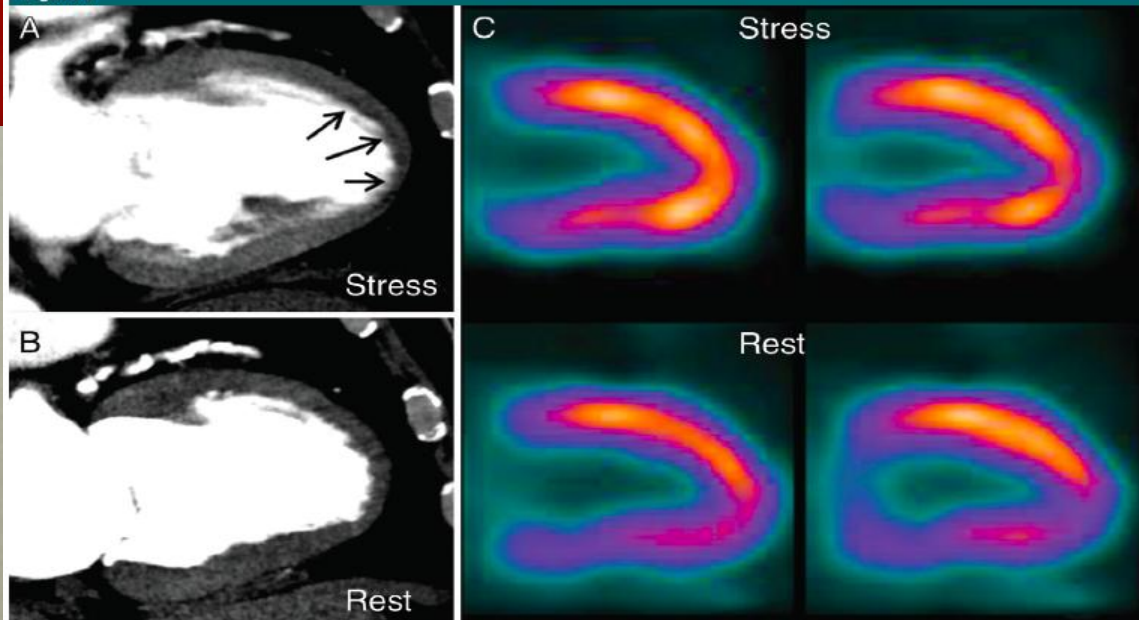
Images in 80-year-old man with chest pain. *A*, Myocardial CT perfusion image at stress demonstrates subendocardial perfusion defect in anteroapical and apical walls (arrows). *B*, Myocardial CT perfusion image at rest shows that defect is reversible. *C*, SPECT images demonstrate normal myocardial perfusion with subdiaphragmatic attenuation artifact. *D*, Image from invasive coronary angiography demonstrates 85% stenosis in proximal left anterior descending artery (arrow).
